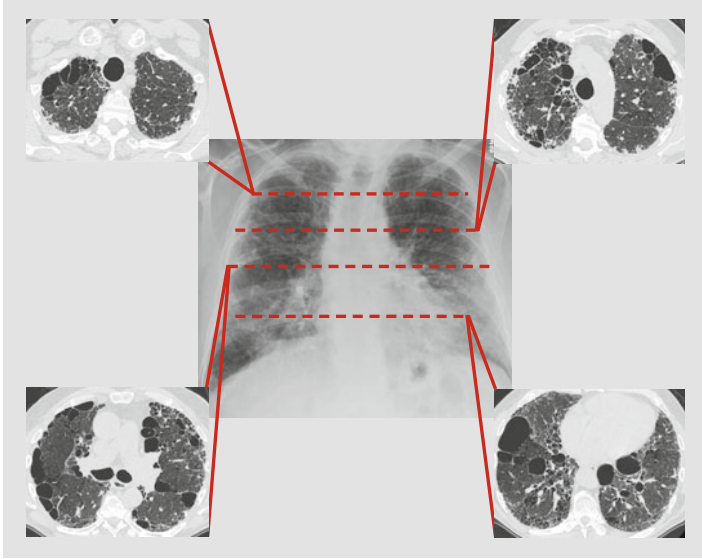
Chest X-ray and computed tomographic imaging demonstrating combined pulmonary fibrosis and emphysema. The computed tomography scan demonstrates typical subpleural fibrosis as well as bullous disease that are characteristic of emphysema
